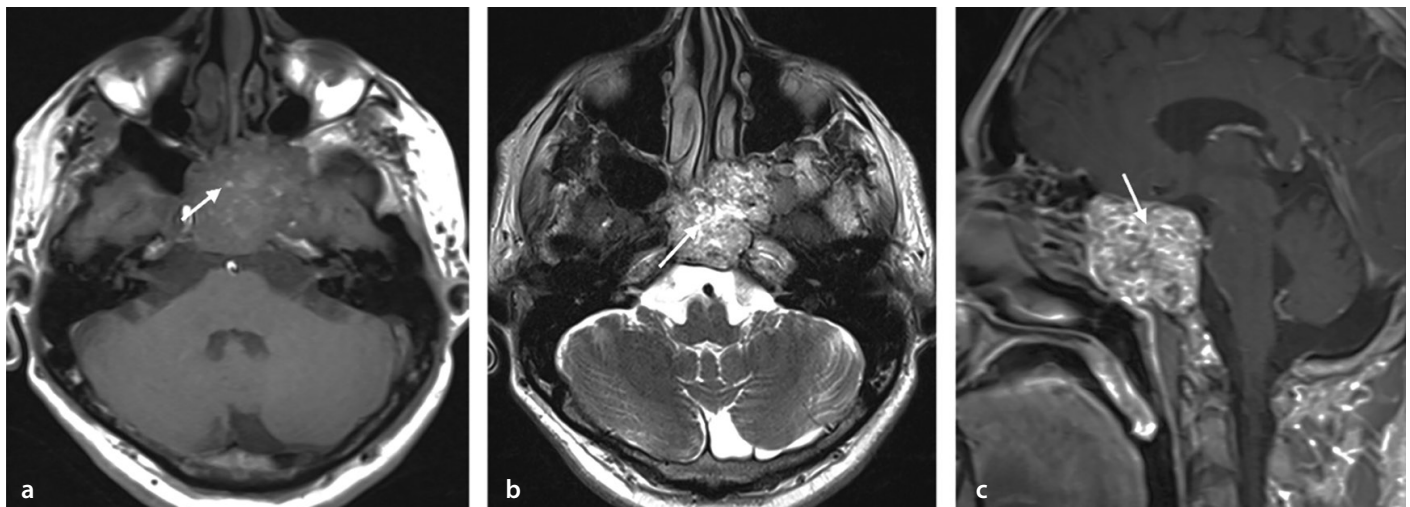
Magnetic resonance images of a 62-year-old male patient with a clival chordoma. The lesion appears hypointense on the T1-weighted (T1W) imaging (a), with punctate hyperintense foci, hyperintense on T2-weighted imaging (b), and demonstrates a honeycomb-like enhancement on post-contrast T1W imaging (c), consistent with a diagnosis of clival chordoma (arrow).
